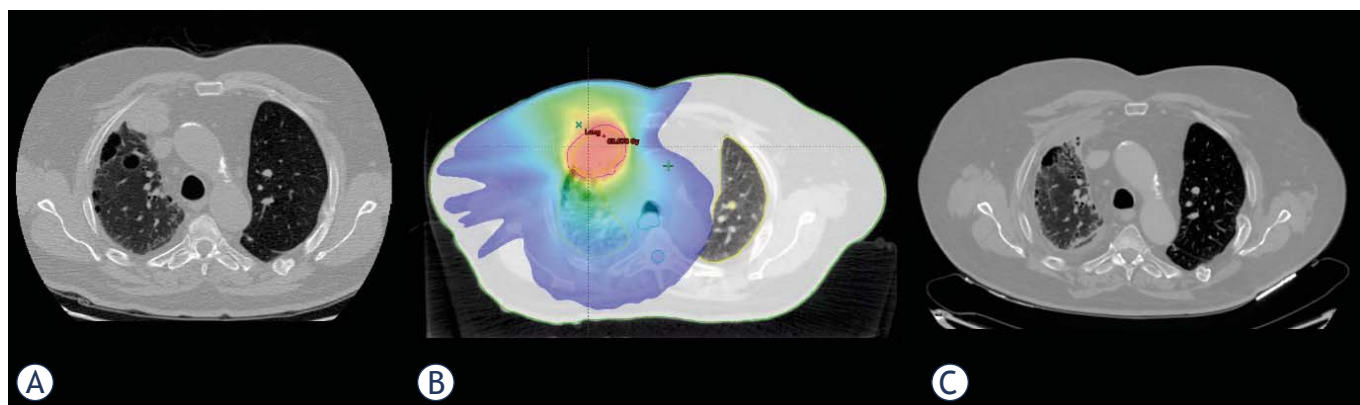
(A) Pretreatment CT demonstrating a mass in the anterior right mediastinum with involvement of the pleura and right upper lobe (B) Radiation field arrangement and dose color wash for SBRT (C) CT 2 months after treatment completion demonstrating regression of the target nodule.
